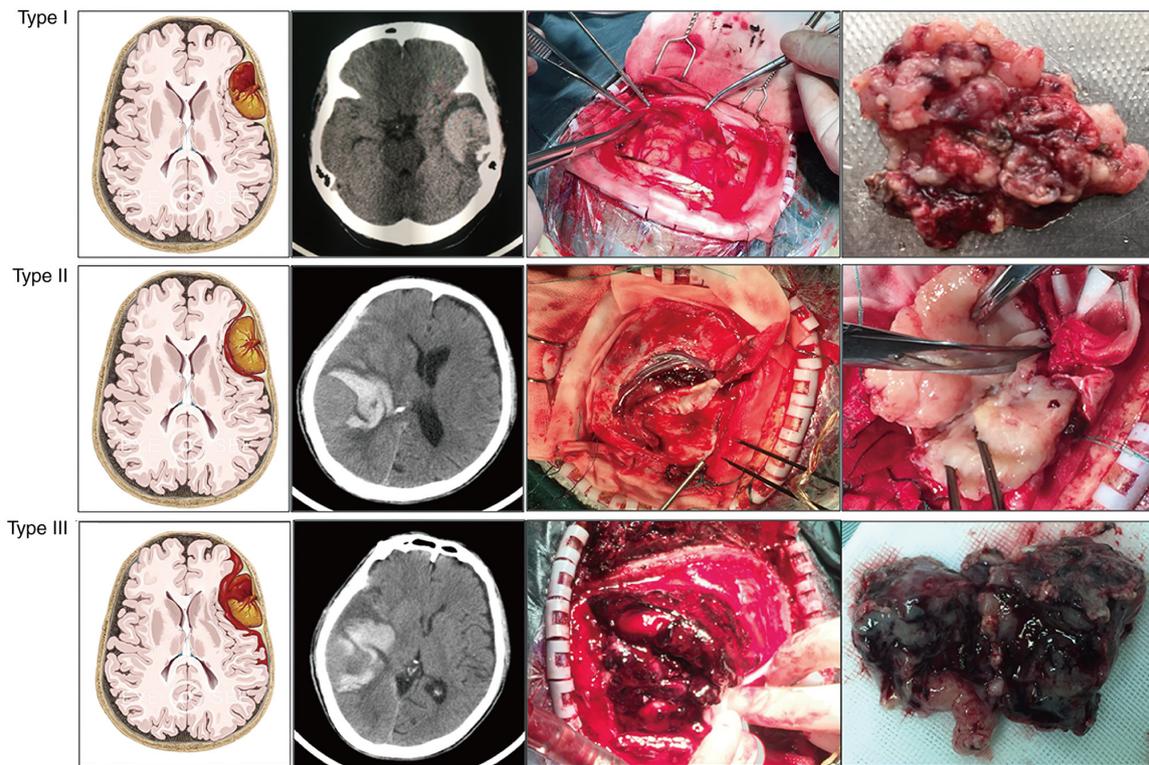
Operative findings associated with corresponding radiological results in different bleeding types. For type I bleeding, the hemorrhage was purely found in the tumor according to the preoperative CT and intraoperatively resected tumor; for type II bleeding, the hemorrhage was purely located in the extra-tumoral region according to the preoperative CT and intraoperatively resected tumor; for type III bleeding, the hemorrhage could be found both in intra- and extra-tumoral regions according to the preoperative CT and intraoperatively resected tumor.
